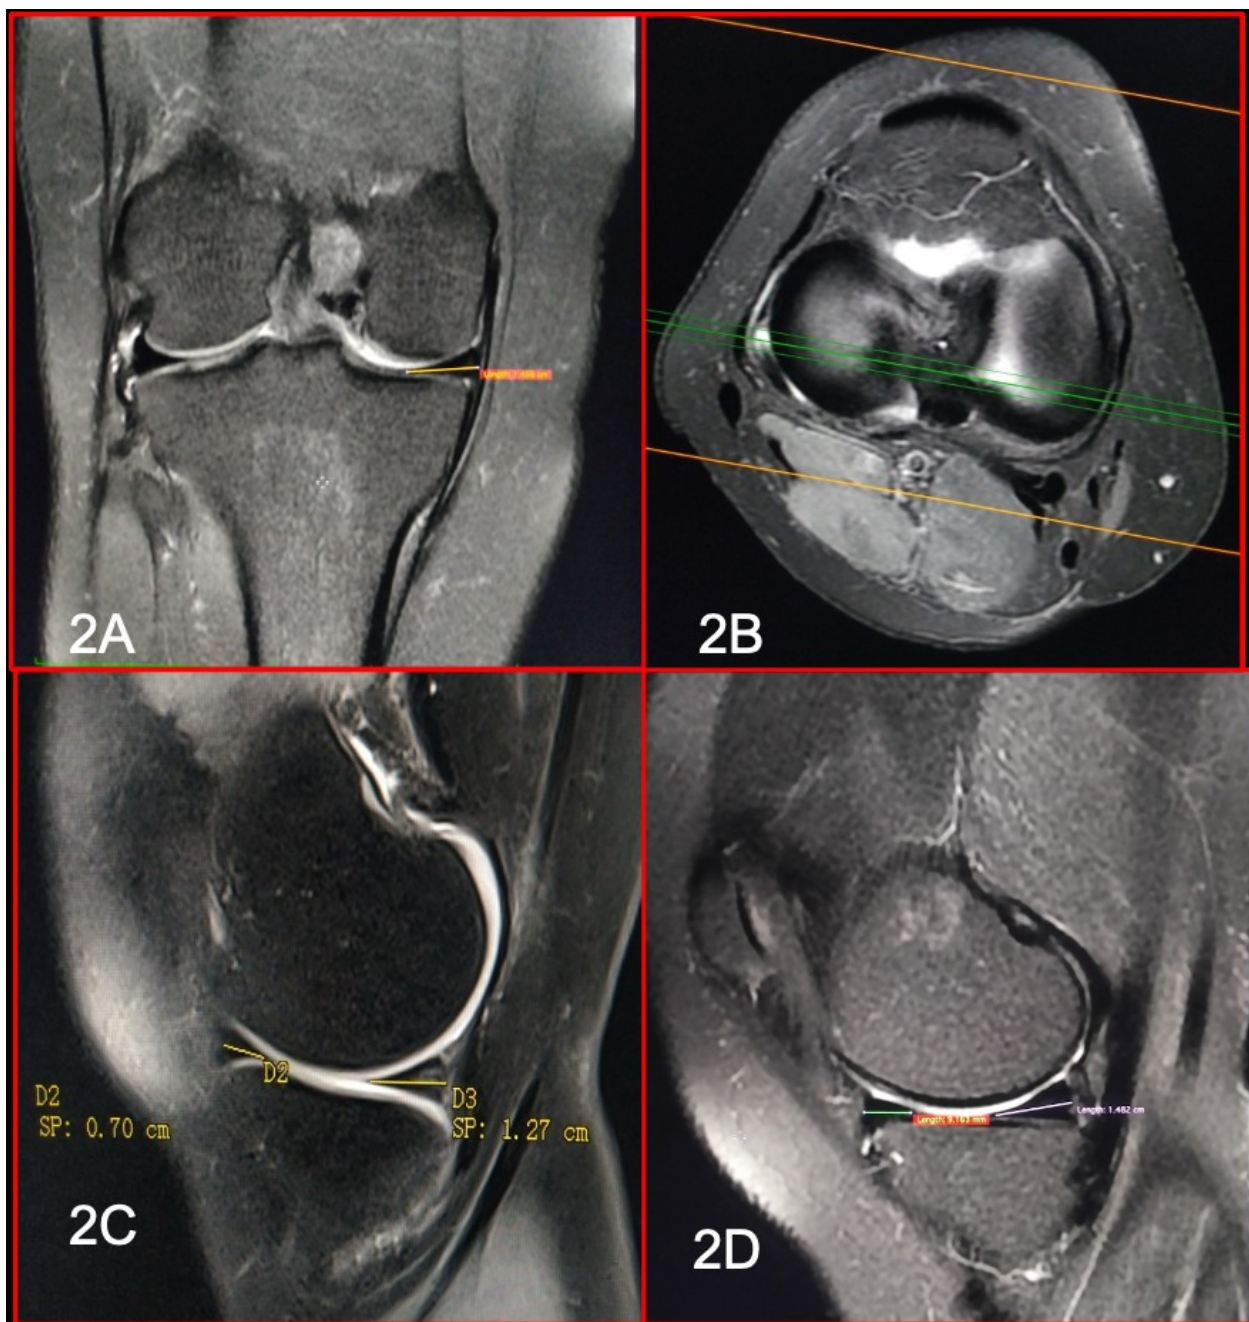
MRI-based measurement technique for medial meniscus posterior horn dimensions in normal menisci.
